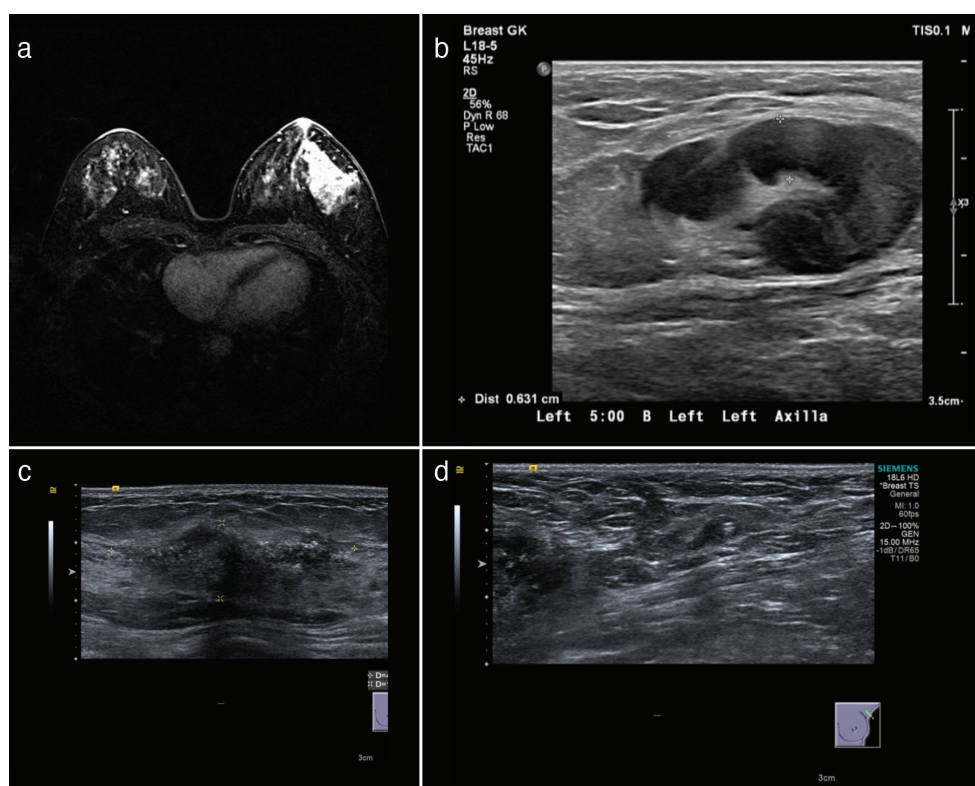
This 45-year-old lady presented with ER-HER2 + T3N1M0 breast cancer. She received 12 weeks of weekly paclitaxel and carboplatin and 3 weekly trastuzumab and pertuzumab followed by surgery that confirmed pCR. (a) MRI prior to treatment demonstrating the large primary tumour; (b) ultrasound scan of the axilla prior to treatment demonstrating the pathological lymph-node; (c) Ultrasound scan of the breast after NST showing non-specific textural change; (d) Ultrasound scan of the left axilla after NST showing a normal giraffe node containing the SAVI SCOUT reflector within it that was subsequently used to guide TAD
